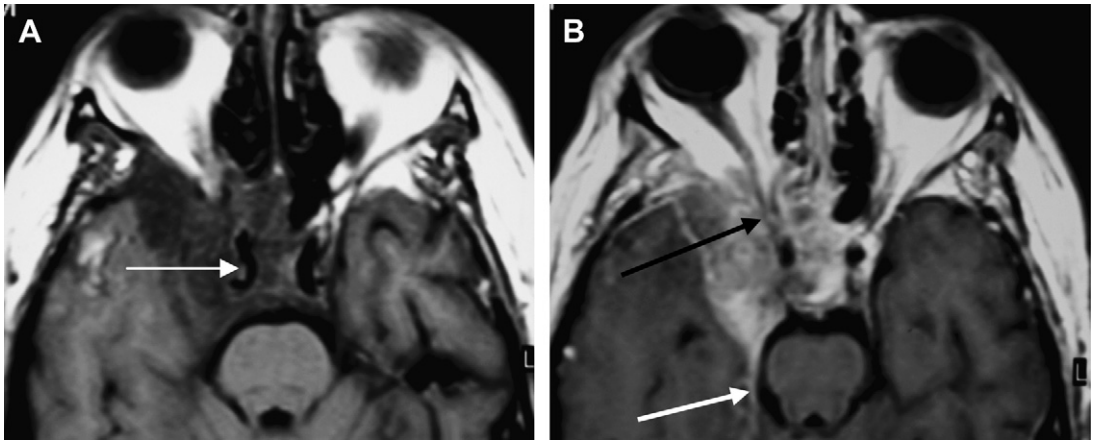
Axial pregadolinium (A) and postgadolinium (B) T1-weighted images show a large sphenocavernous lesion on the right extending anteriorly into the orbital apex and sphenothmoid sinuses, laterally into the middle cranial fossa and lateral wall of the orbit, and posteriorly along the right tentorial leaflet. The lesion encases the right cavernous carotid without narrowing its lumen (*white arrow in A*) and replaces the body of the sphenoid, clivus, and greater sphenoid wing. Postcontrast enhancement is slightly heterogeneous, and a dural tail is noted along the tentorium (*white arrow in B*). Note the encasement and compression of the optic nerve at the optic canal (*black arrow in B*) and secondary proptosis (intradiploic sphenocavernous meningioma).
